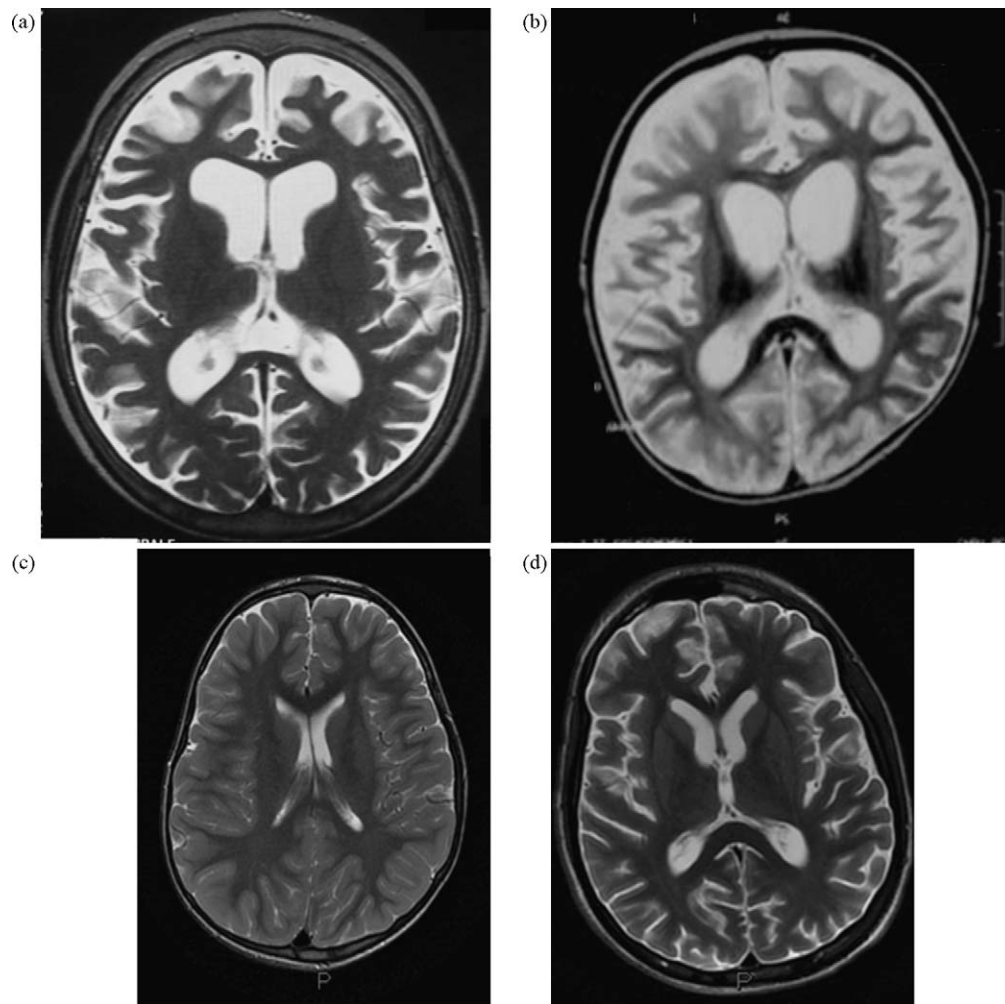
MRI of patients 2 and 3 after complicated SE (a, b) on T2 weighted sequence compared to normal (c) and acute anoxic-ischemia at the same age (d). MRIs (a, b) were performed at mean 6 weeks after the event. The MRI of patients with DS (a, b) shared severe cortical atrophy similar to that of postanoxic-ischemic lesions but in addition dramatic loss of white matter with slight basal ganglia atrophy.
